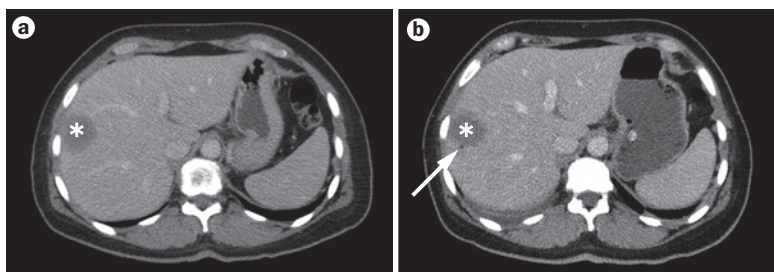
Thermal ablation of hepatic metastasis in a female patient with breast cancer. a | This preoperative CT image shows an area of low attenuation (asterisk) in the right lobe of the liver, which represents a metastasis. This was treated with a radiofrequency electrode for 12 minutes. b | Following radiofrequency ablation, the tumour has been coagulated. As observed in the postoperative CT image, the region is now of lower attenuation and contains a small bubble of gas at its inferior margin (arrow). The area of low attenuation appears slightly larger than before treatment, as the coagulated area exceeds the size of the tumour.
